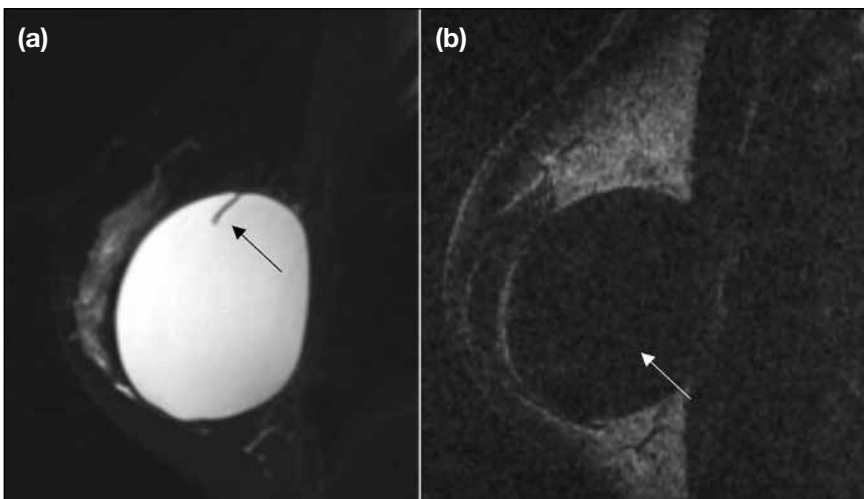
Saline breast implant. These are the characteristic signals of saline on silicone-suppressed, saline-only (a) and silicone-only, water-saturated (b) magnetic resonance imaging sequences, with hyperintense saline on the T2-weighted fat-suppressed, silicone-suppressed, saline-only sequence and hypointense saline (white arrow in [b]) on the T2-weighted short-tau inversion recovery silicone-only, water-saturated sequence. Also note the 'radial fold', a curved hypointense line running from the periphery and perpendicular to the implant shell (black arrow in [a]), which is a normal finding and should not be misinterpreted as rupture.
